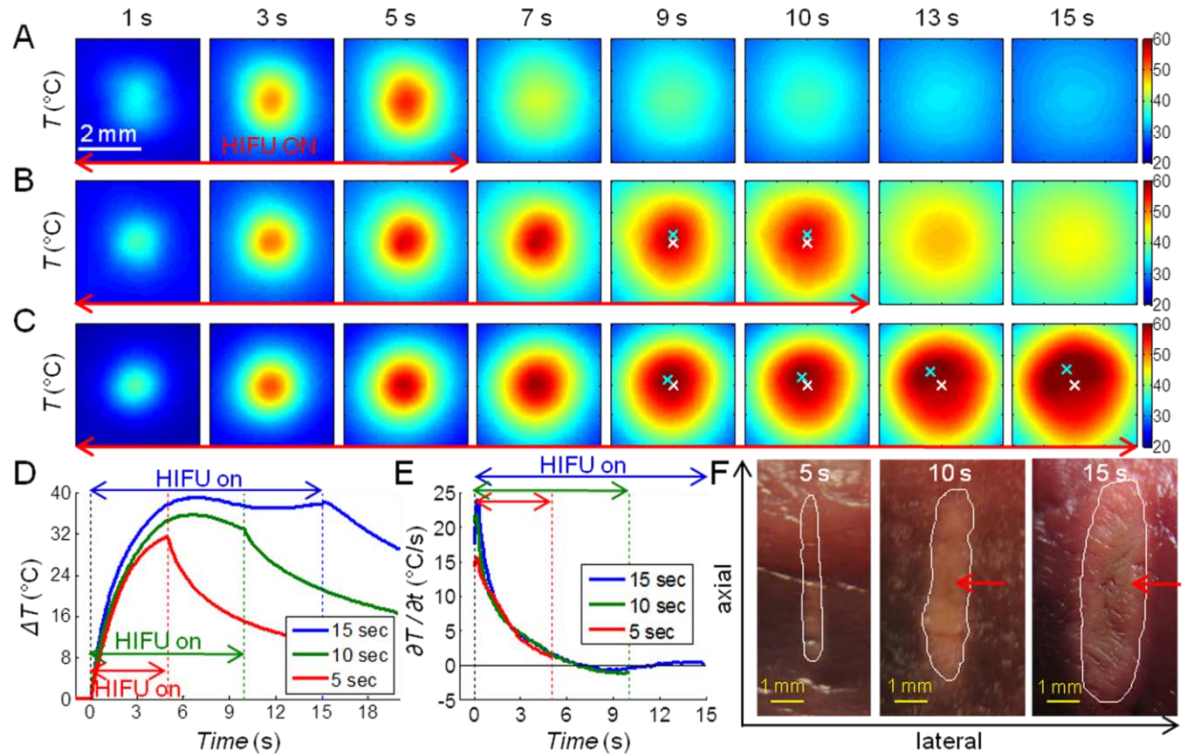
Three sets of IR images of temperature T (°C) during ablative HIFU exposures (1500 W/cm^2) with the focus placed at 5 mm beneath the surface. Duration of HIFU exposures is (A) 5 s, (B) 10 s, and (C) 15 s. The spatial peak temperature (cyan cross) and the original center focus (white cross) are indicated in (B) and (C). (D) Time evolution of the temperature change $\Delta T(t) = T(t) - T(t=0)$ and (E) the rate of temperature change $\partial T/\partial t$ (°C/s) at the center of the temperature distribution. (F) Gross images of the lesion cross-sections. The white contours indicate manually-drawn lesion boundaries, and the red arrows indicate regions with discoloration, suggesting overheating. Axial is the direction which ultrasound beams propagated, from the bottom surface of the tissue to the top surface.
